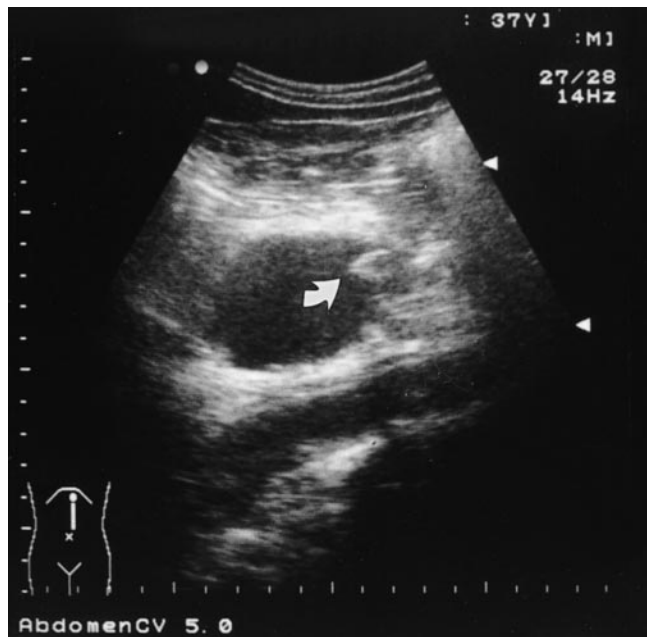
Ultrasonography shows a papillary projection in the cyst in the head-to-body region of the pancreas (arrow)
